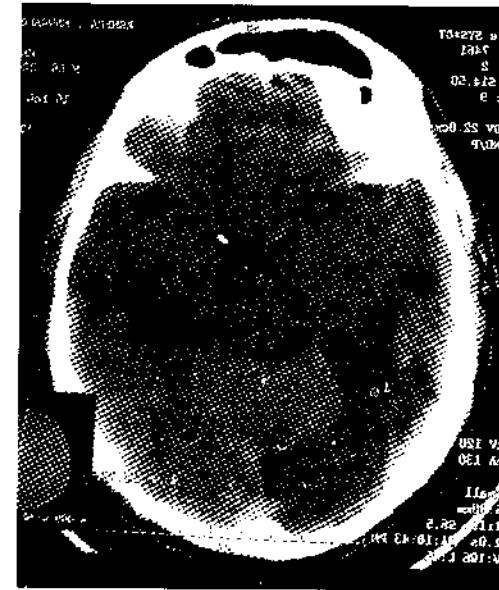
CT scan images with patients of cerebral infarction
